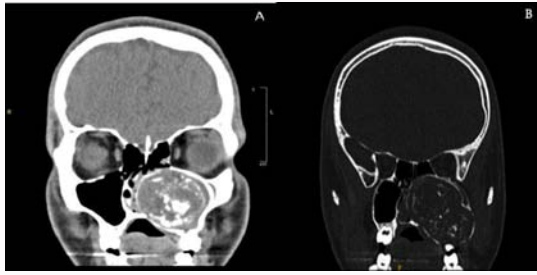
Imaging examinations of odontogenic carcinoma with dentinoid. (A) Computed tomography scan (coronal section), showing involvement of the left orbit and left septum by the tumor. (B) Computed tomography scan (coronal section), showing the heterogeneously enhancing mass centered within the left maxillary sinus.
